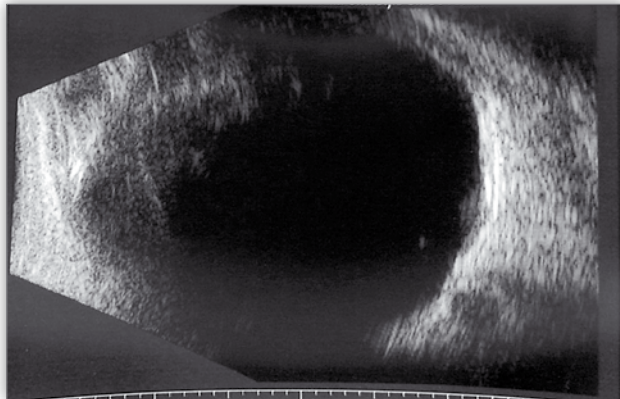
Ultrasound of the right eye.
